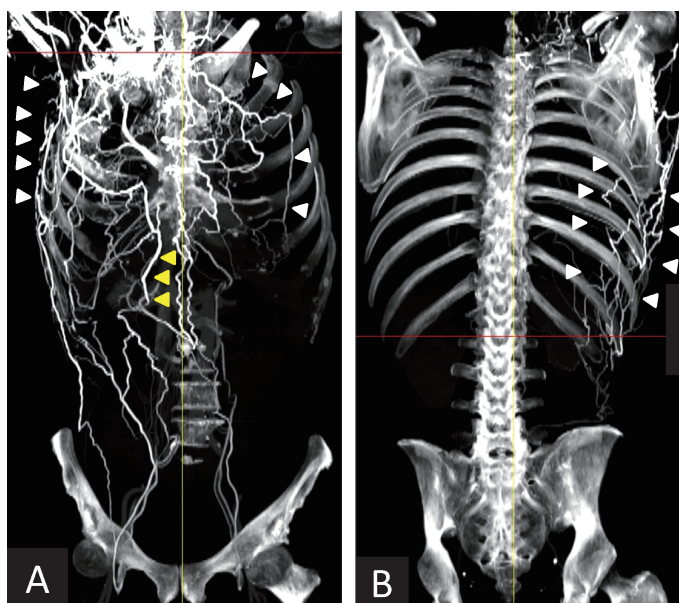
Preoperative contrast-enhanced CT angiography
